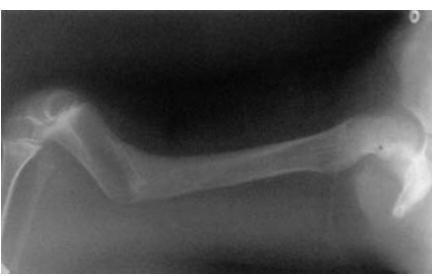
Lateral radiograph of a dogleg-type deformity after distal femoral extension osteotomy.
